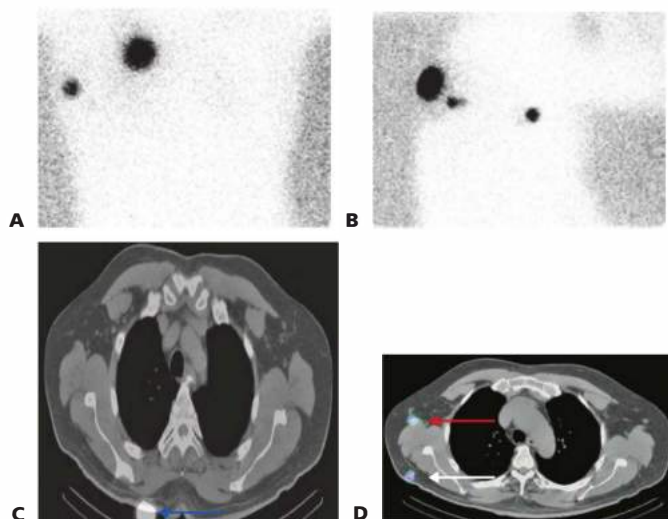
• SPECT-CT lymphoscintigraphy. Planar lymphoscintigraphy of primary melanoma is shown in the top row, with anterior view in (A) and lateral view in (B). Selected SPECT-CT images of the same patient are seen in the bottom row. Only the axillary SLN is seen in (A) and an additional SLN is seen in (B), which was obscured by the overlying activity transmitted to the axilla from the injection site. The additional SLN in (B) is likely an in-transit node, the exact anatomic location of which is better visualized in the transaxial view of the SPECT-CT image in (D). In (C), the *blue arrow* indicates the injection site and in (D), a few cross-sectional images inferior the *white arrow* identifies the in-transit SLN and the *red arrow* the axillary SLN, both of which are located in the same A-P visual plane.
